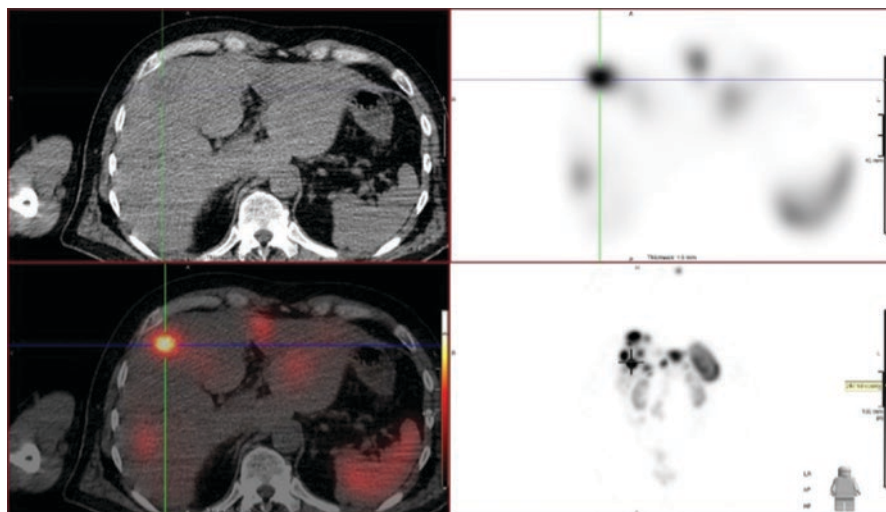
Multiplanar reconstructions of an octreotide SPECT-CT scan demonstrating strong radiotracer uptake in a focal liver neuroendocrine metastatic deposit (crosshairs). Less avid uptake in other neuroendocrine metastatic deposits seen around this lesion
